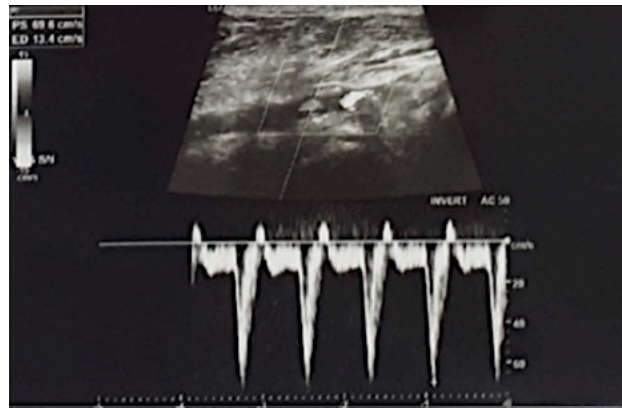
Findings from Color Doppler Ultrasound examination follow-up (pulse). (Note: Follow up of popliteal artery angioplasty. High intensity of arterial flow stated the patency of the vessel).
